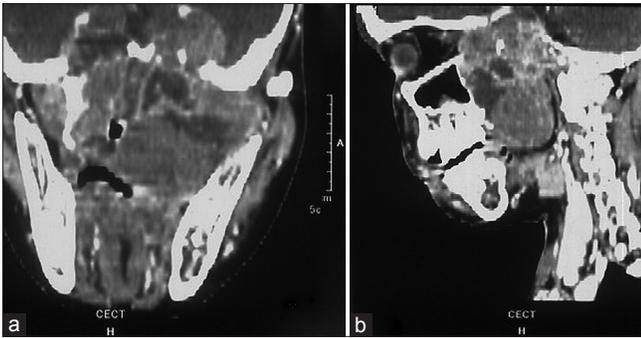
(a and b) CT scan showing erosion of base of skull with extracranial extension
